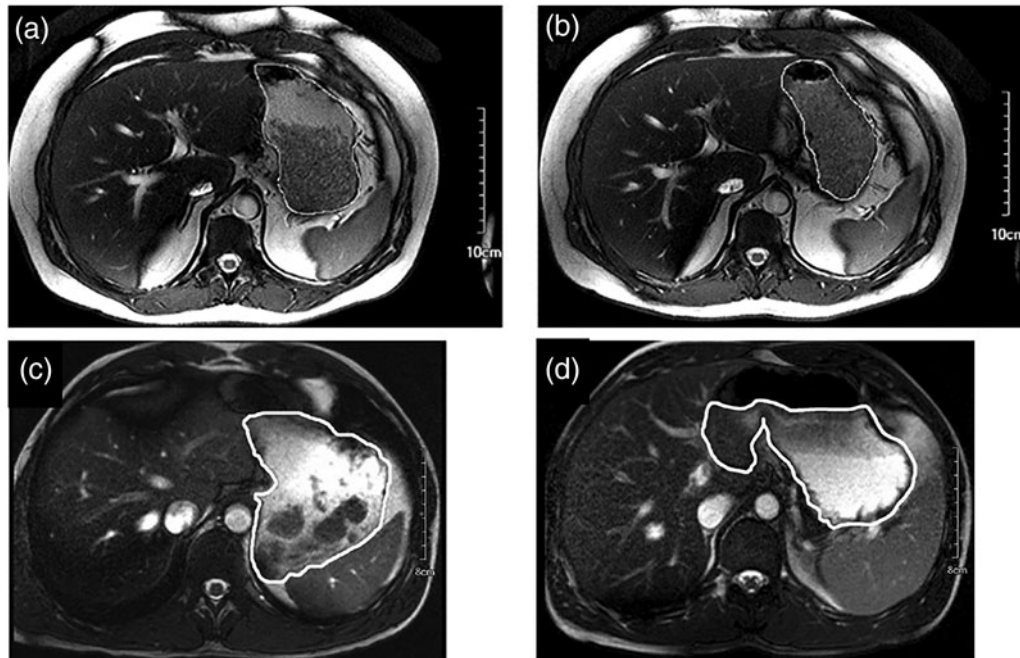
Axial FIESTA (Fast Imaging Employing Steady-state Acquisition) MRI images of the stomach (outlined) taken 5 min (A) and 25 min (B) post-consumption of oat flake porridge. Image (A) shows a layer above the oat flake porridge that is not apparent after 25 min (B). Axial TrueFISP (True Fast Imaging with steady state precession) MRI images of the stomach (outlined) taken 5 min after consumption of a semi-solid (C) or liquid (D) version of the same meal.
